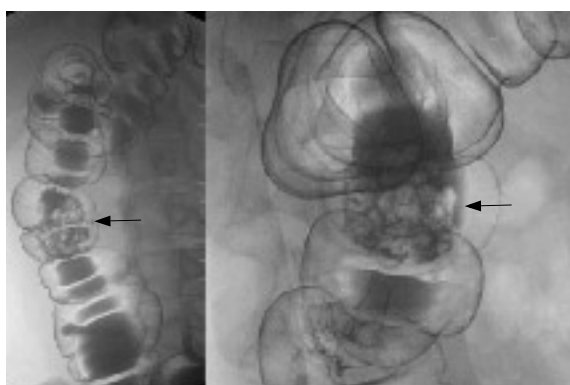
Double-contrast radiograph of the ascending colon showing an about 40 mm lobulated peduncular polyp (arrow).
